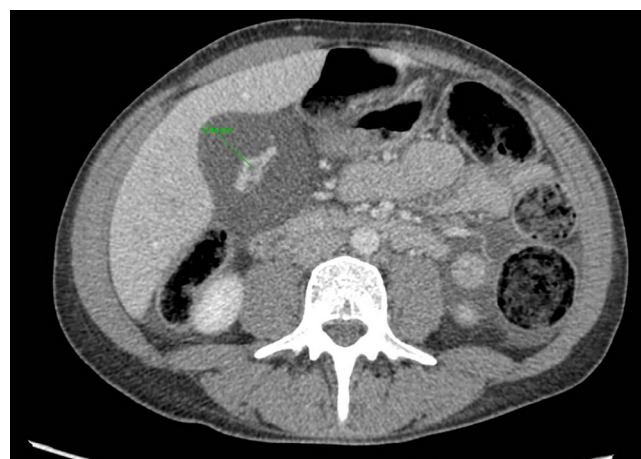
A computed tomography scan with contrast demonstrating marked gallbladder wall thickening (33 mm) with a hyperdense collapsed lumen.
